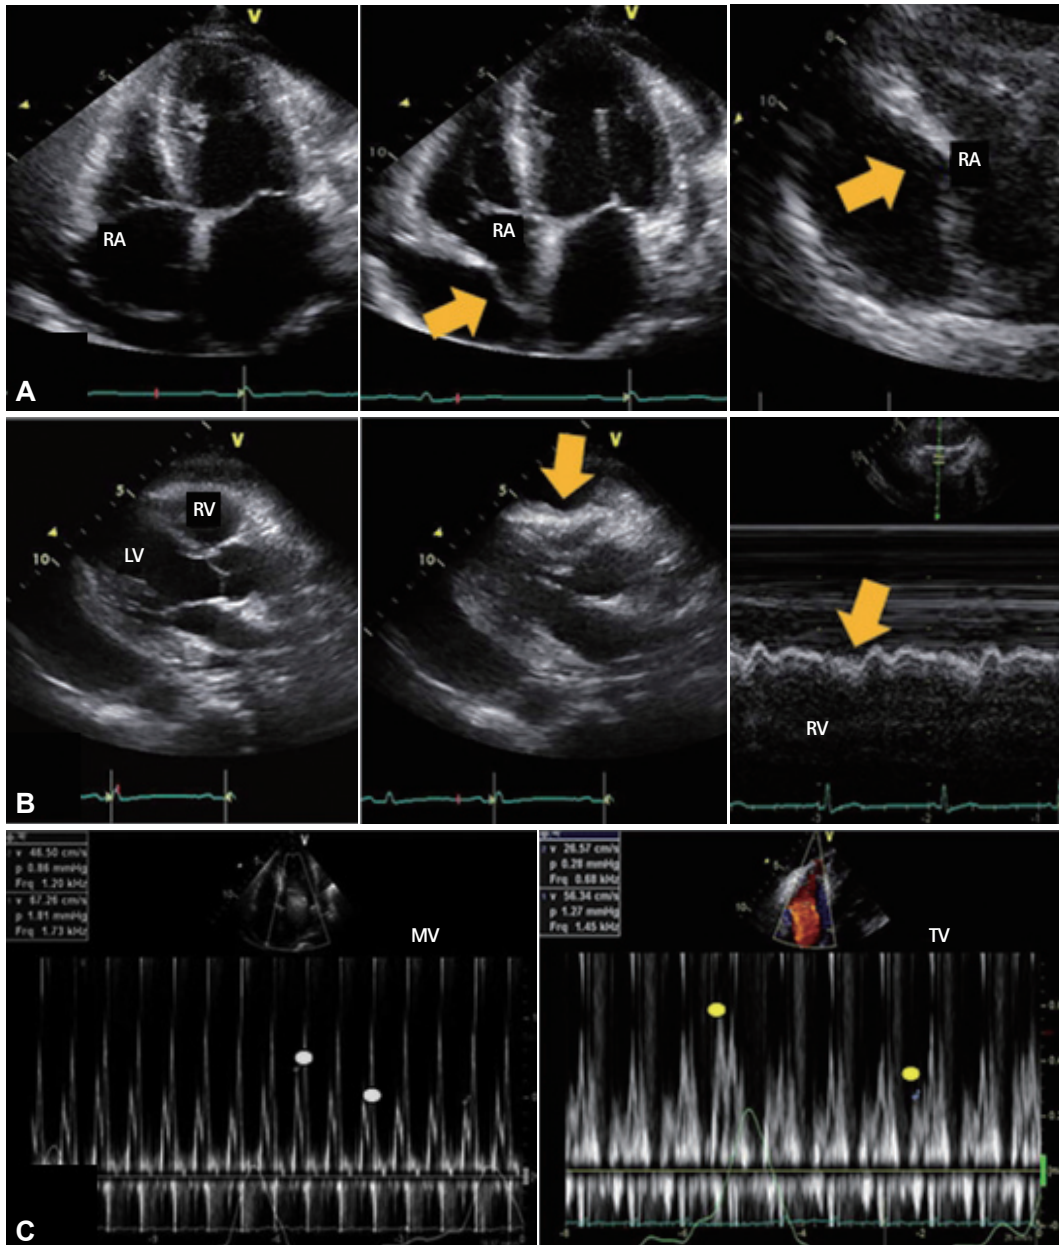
Representative echocardiographic images of cardiac tamponade. A: diastolic collapse of the free wall of the right atrium from late diastole to early systole is observed on the apical 4 chamber view (middle) and magnified view (right), compared with the image of early diastole (left). B: collapse of the right ventricle in early diastole is observed on the parasternal long axis view (middle) and M-mode (right), compared with the image of systole (left). C: marked respiratory variation is observed on the transmitral (left) and transtricuspid (right) Doppler flow. RA: right atrium, RV: right ventricle, LV: left ventricle, MV: mitral valve, TV: tricuspid valve.
